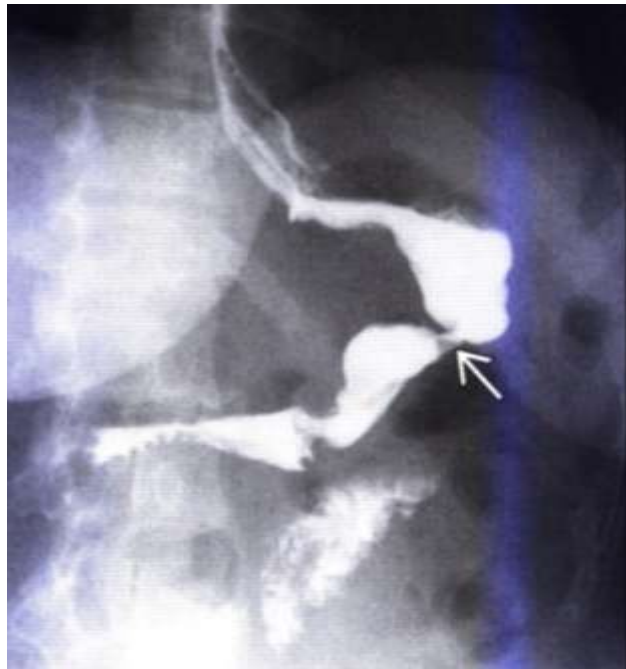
Sleeve resection of the stomach, in which 75% of the stomach is removed by cutting it along the length of the axis. The remaining part of the stomach in the form of a "banana" has a volume of about 100 ml. On a standing radiograph of a patient who recently underwent a sleeve gastric resection, a reduced stomach in the form of a "banana" is visualized, with a narrowing at the end of the suture line in a limited area. Such strictures are usually "soft" and transient, even if balloon dilatation was required in this case.
